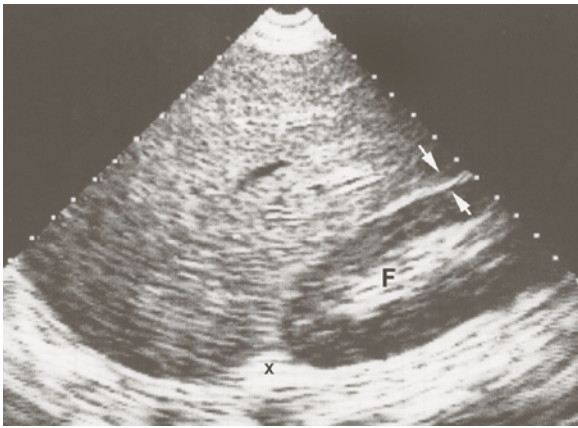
Liver and right kidney. Longitudinal scan. The kidney has a normal size in its long axis, regular boundaries, a mildly echoic peripheral area, an echoic internal area (*F*). The interface (*arrows*) between liver and kidney (Morrison's space) should not be confused with the diaphragm. The technique of lung ultrasound, described in pages 117–127, makes this mistake impossible. Note for the expert level: the adrenal area (*X*)
